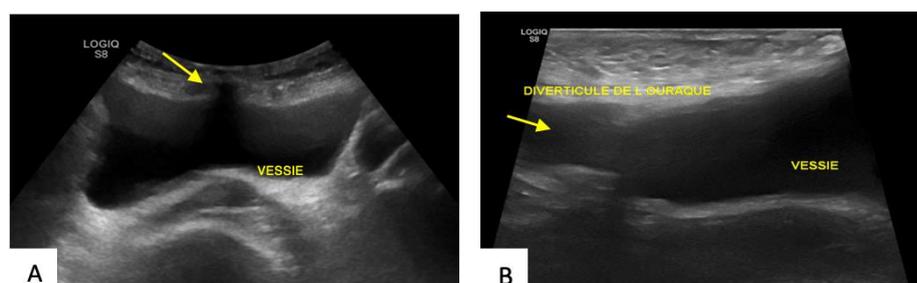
Axial (A) and sagittal (B) ultrasound views of the bladder demonstrating a diverticulum arising from the anterosuperior wall
